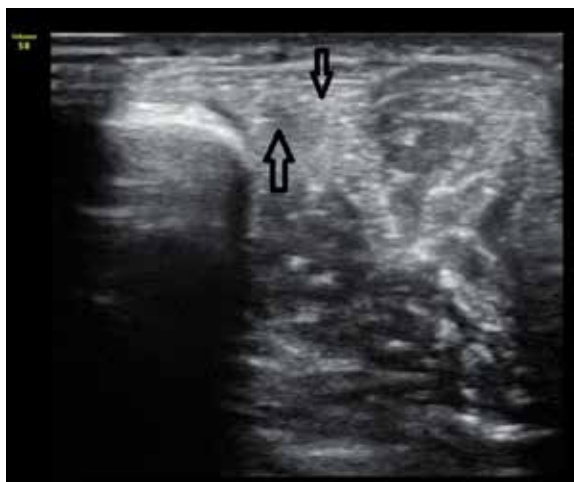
Axial sonogram of the anterior leg – patient lying in the supine position, shows a defect (black arrows), measuring approximately 9.5 mm, in the fascial sheath of the tibialis anterior muscle.
